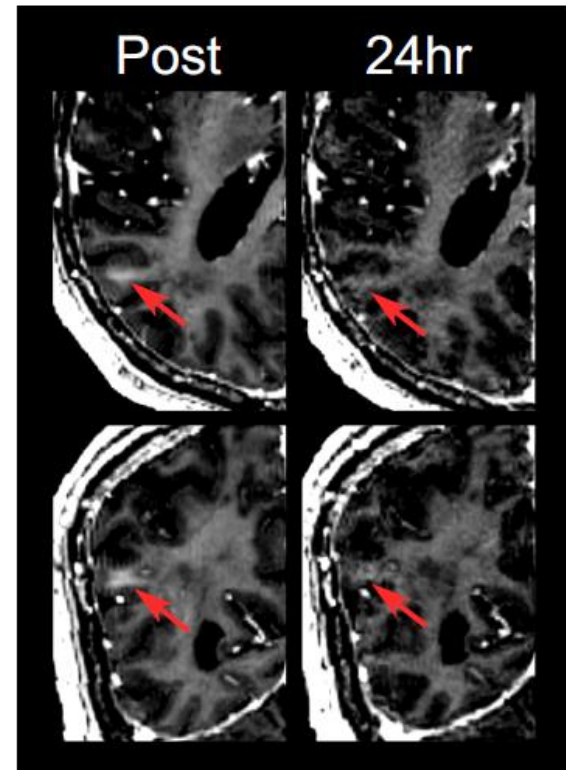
Gadolinium-enhanced T1-weighted images: blood-brain barrier opening. Post: Blood-brain barrier opening of patient 2 in the targeted area immediately after sonication. 24 h: Same targeted area of patient 2, 24 h after treatment, without recognizable BBB opening. Top and bottom panels, respectively, show axial and coronal views of the parieto-occipito-temporal region.
